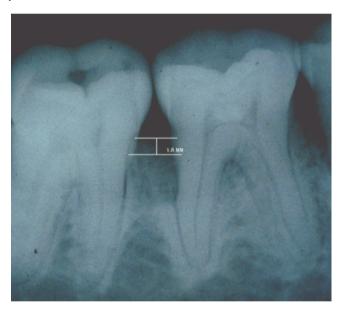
Radiograph after 9 month showing IBD = 1.8 mm with linear measurement by Scion image analyzer.
